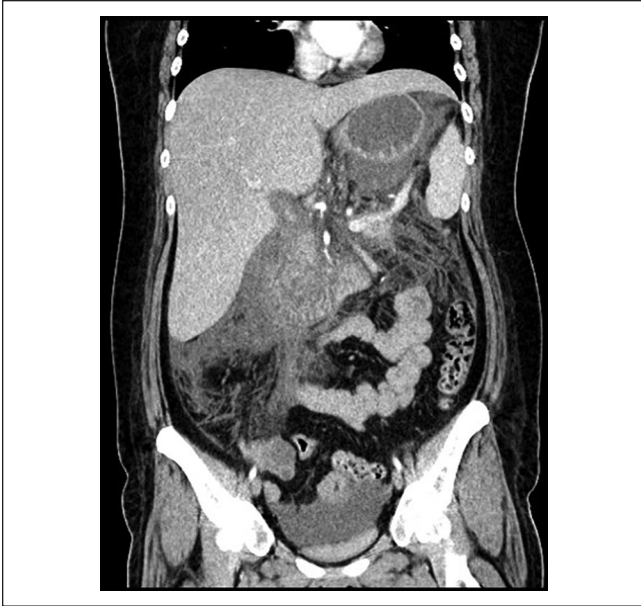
Computed tomography of the abdomen and pelvis coronal view showing extensive peripancreatic fluid collection.
